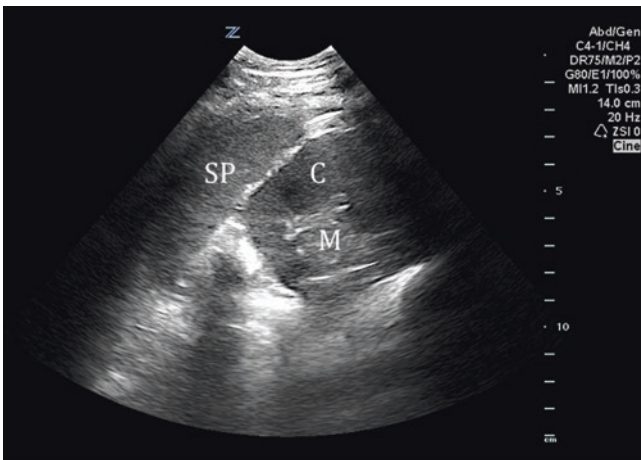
Ultrasound image of the left kidney in the transverse plane. This view similarly demonstrates the cortex (C) and medulla (M) of the kidney. The spleen (SP) is once again visible superior to the kidney. See Video 28.4. (Image courtesy of Stephen Alerhand.)
